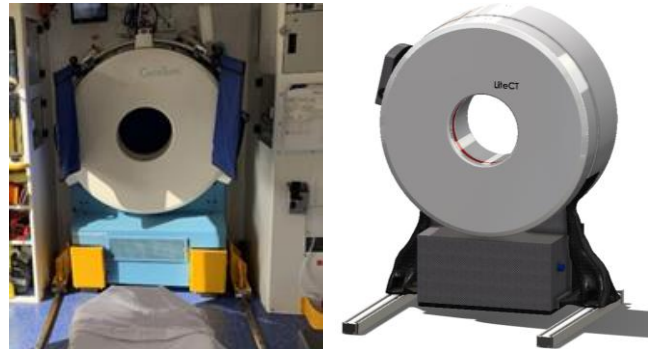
A: shows a commercial CT scanner (The image has been reproduced under a creative commons licence (CC BY 4.0) from [4] and B: a re-designed lightweight CT scanner
